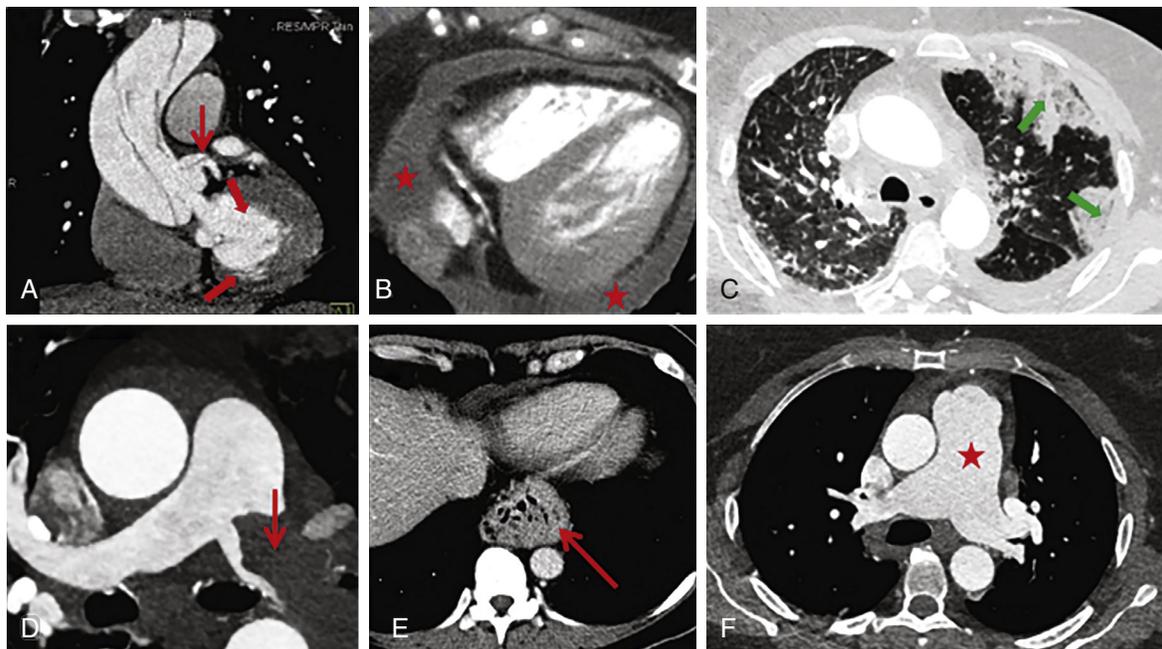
Examples of various etiologies of chest pain or dyspnea diagnosed on cardiac computed tomography. A, Aortic dissection extending into the left main coronary artery. B, Pericardial effusion. C, Pulmonary infarction. D, Pulmonary embolus. E, Hiatal hernia. F, Dilated pulmonary artery in a patient with pulmonary hypertension.
